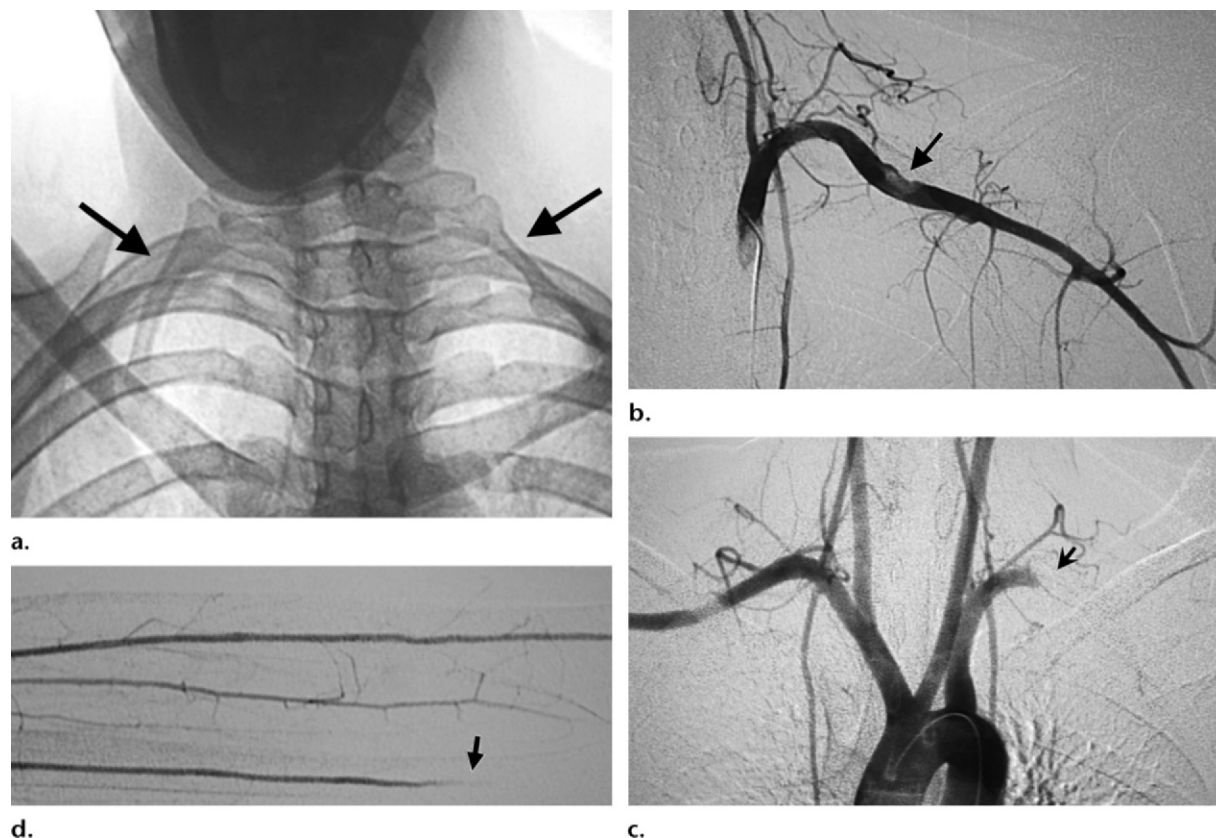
TOS due to arterial compression in a 20-year-old woman with acute left arm pain that intensified with exercise. (a) Radiograph shows bilateral cervical ribs (arrows). (b) Arteriogram obtained at DSA with the arm in a neutral position shows a thrombus (arrow) with irregularity and aneurysmal dilatation of the left subclavian artery. (c) Arch aortogram obtained at DSA with elevation and abduction of the arm shows complete left subclavian artery occlusion (arrow). (d) Arteriogram obtained at DSA shows embolism (arrow) of the distal left ulnar artery.
